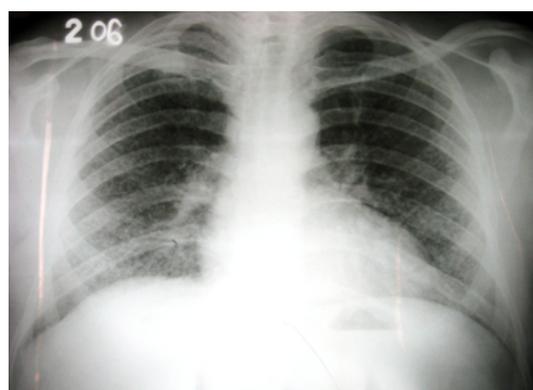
Number 1 technician's chest X-ray.
